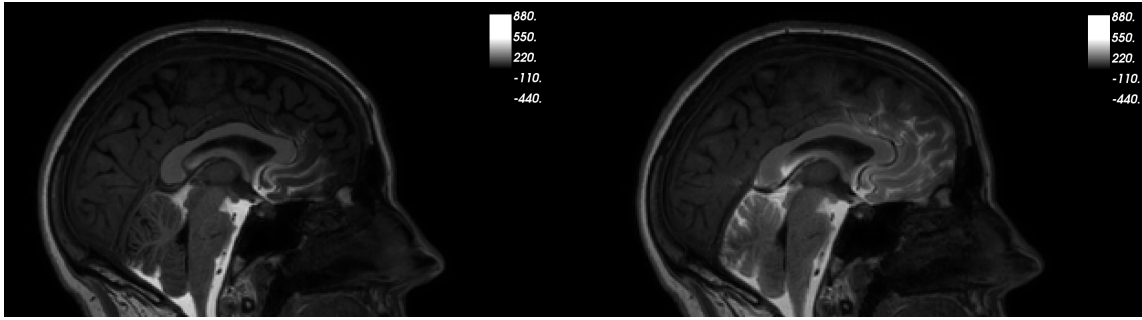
The left panel shows a MRI the patient's head with MRI-contrast after 1 hour. The right panel shows a MRI the patient's head with MRI-contrast after 6 hours.
